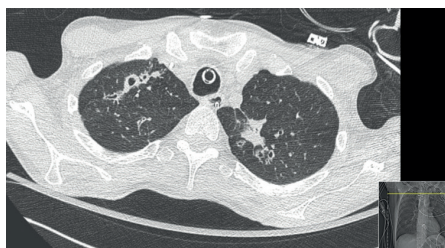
Computed tomography image of fibrocavitary disease exhibiting extensive lung destruction with large cavities.
